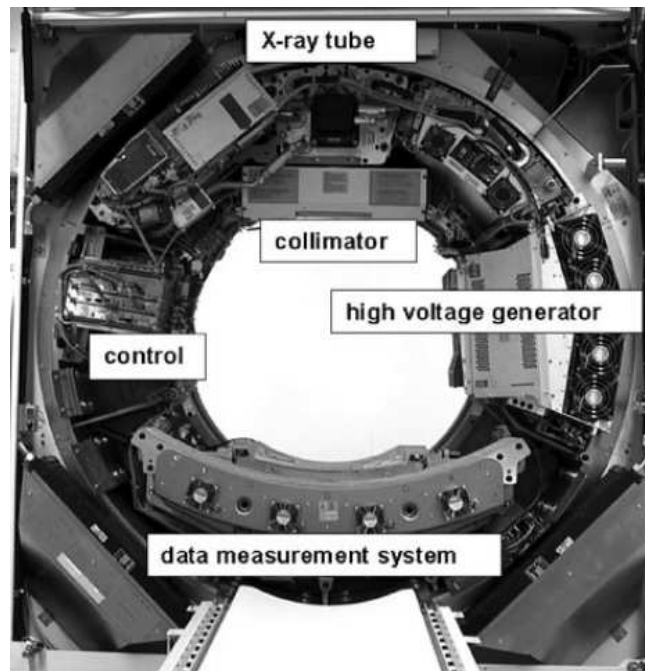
View of the gantry without its safety housing. The gantry weighs about 1,000-2,000 kg and rotates rapidly around the patient, comprising the X-ray system (X-ray tube, collimator and filters), the detector system, the high voltage generator and mechanical supports. (source: Ulzheimer; Flohr, 2009²⁰).
